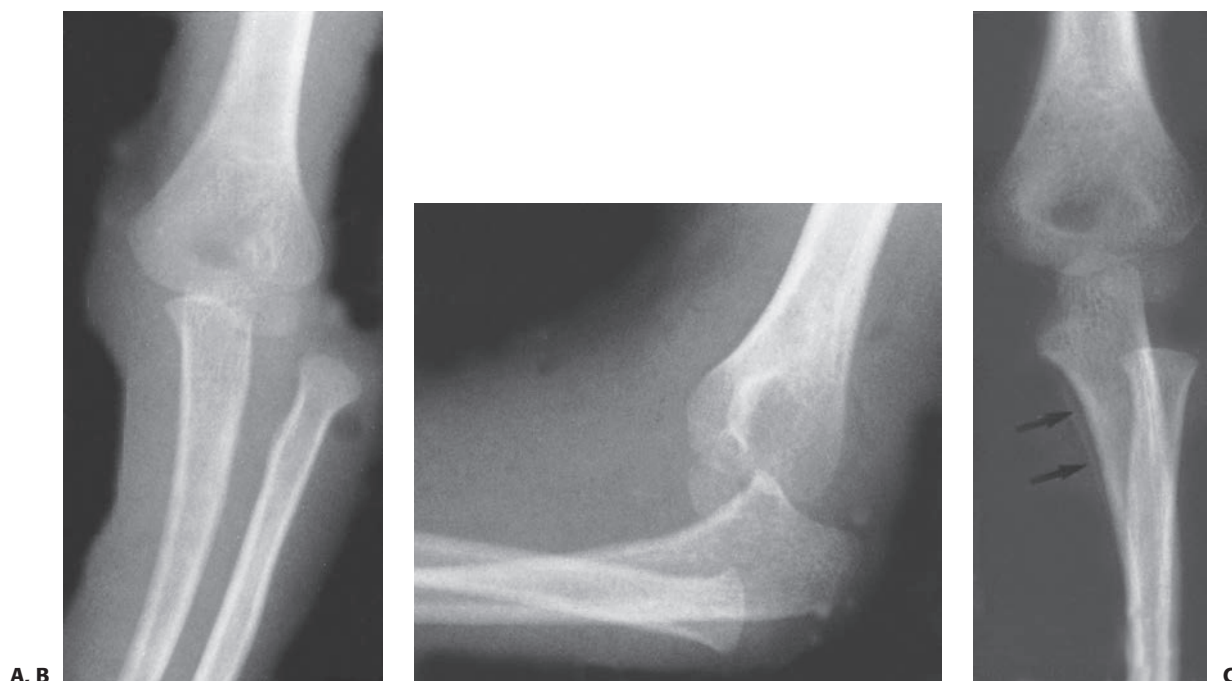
Medial-lateral divergent dislocation. A: Anteroposterior view demonstrating disruption of the proximal radioulnar joint with the radius lateral and the ulna medial. B: Lateral radiograph confirms that the radius and ulna are both posterior to the distal humerus. C: A radiograph taken 4 weeks after injury shows periosteal new bone formation (*arrows*), indicating where the soft tissues were extensively torn away from the proximal ulna.
